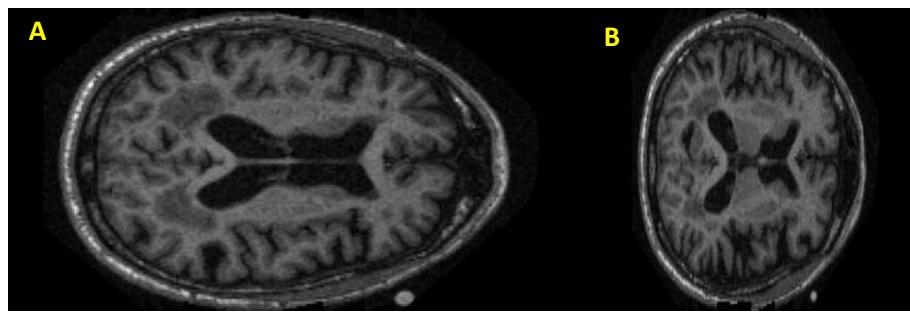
MRI Image Samples of Alzheimer's A) before preprocessing and B) after preprocessing
